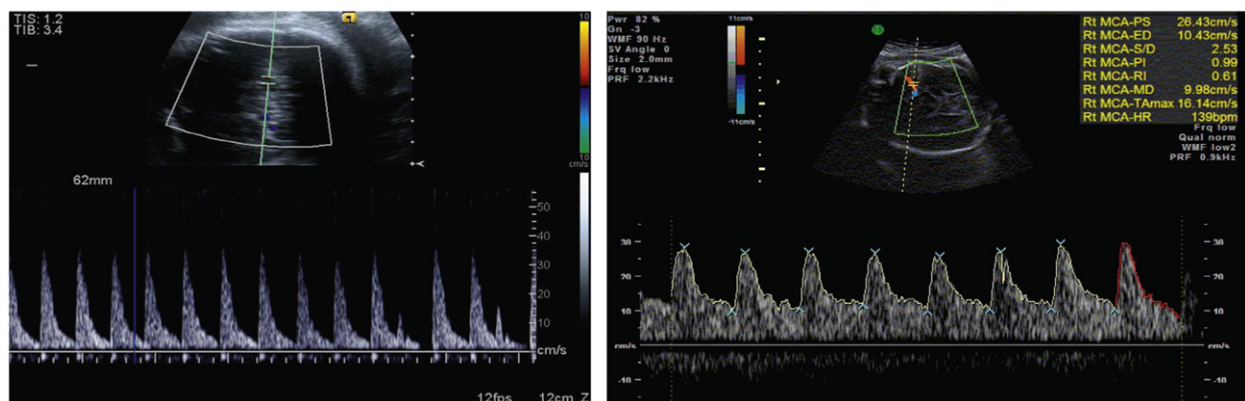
MCA Doppler from a normal fetus, showing little end diastolic flow, and a growth restricted fetus, with cerebral redistribution demonstrated by increased end diastolic flow.
